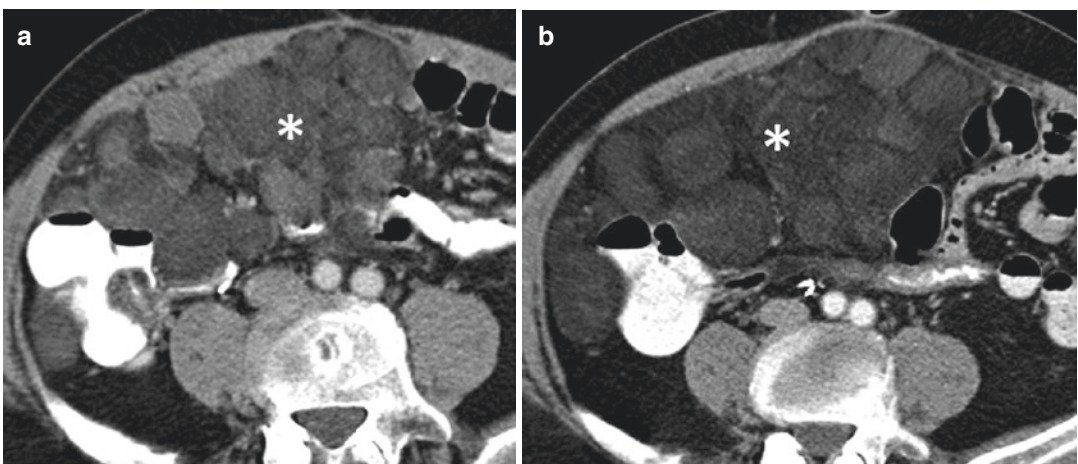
62-year-old man with myxoid liposarcoma treated with trabectedin. (a, b) Axial contrast-enhanced CT images at baseline and 12 months after start of treatment
